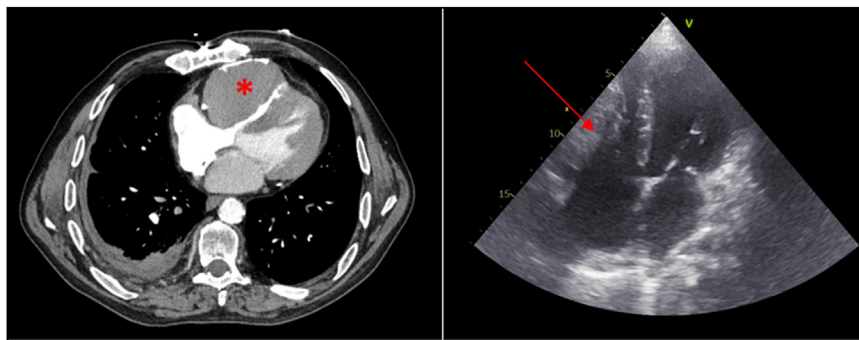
Thoracic computed tomography at admission (left) and transthoracic echocardiogram (right). These exams show compression of right ventricle cavity by a fibroelastoma originating from the right ventricle free wall (indicated by red asterisk and red arrow).
